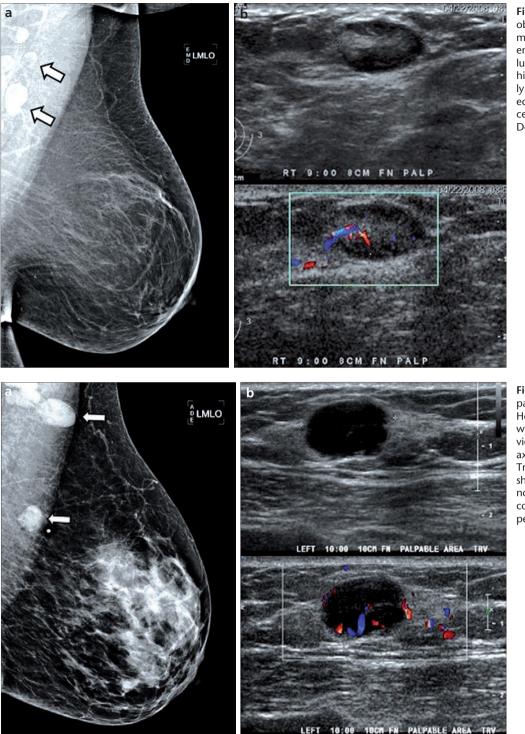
a, b. Mediolateral oblique (MLO) view of a mammogram (a) shows slightly enlarged lymph nodes with a lucent center due to the fatty hilum (*arrows*). On US normal lymph-node is seen with its echogenic fatty hilum, and central flow is noted on Color Doppler US (b).
